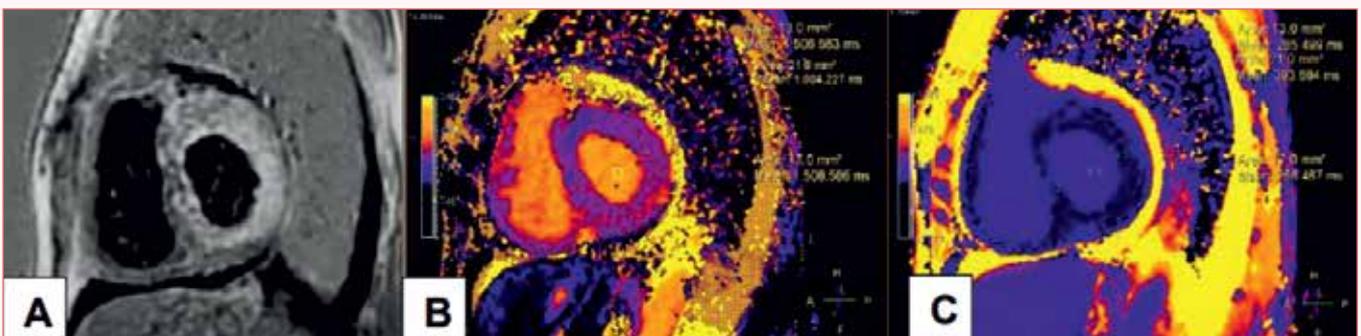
57 years old female with LV hypertrophy, Bi-atrial enlargement and dilated IVC on echocardiography, mild bilateral pleural effusion and normal coronaries on CAG. Diffuse subendocardial enhancement in LV on LGE (A), Parametric mapping (B,C) with Native T1 of 1510-1950 ms, Post-contrast T1 of 285-340 ms and increased ECV fraction -45% led to diagnosis of Cardiac Amyloidosis.
